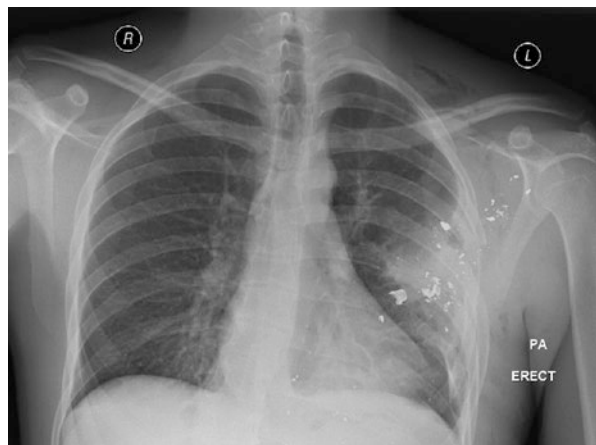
Radiograph of the chest following a gun-shot wound where the round has struck a rib, causing a rib fracture and fragmentation of the round. This has resulted in significant energy transfer resulting in lung contusion. © 2017 Crown Copyright
